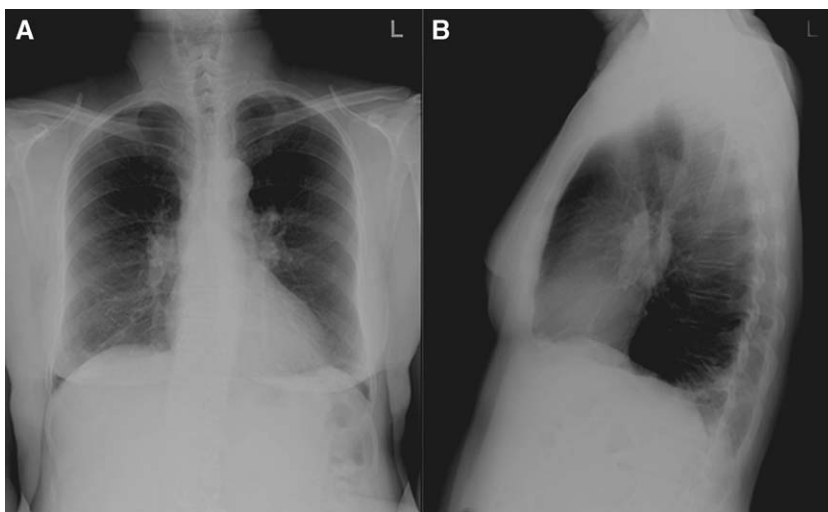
Sarcoidosis. Chest radiographs (posteroanterior [A] and lateral [B]) show bilateral hilar lymphadenopathy.
